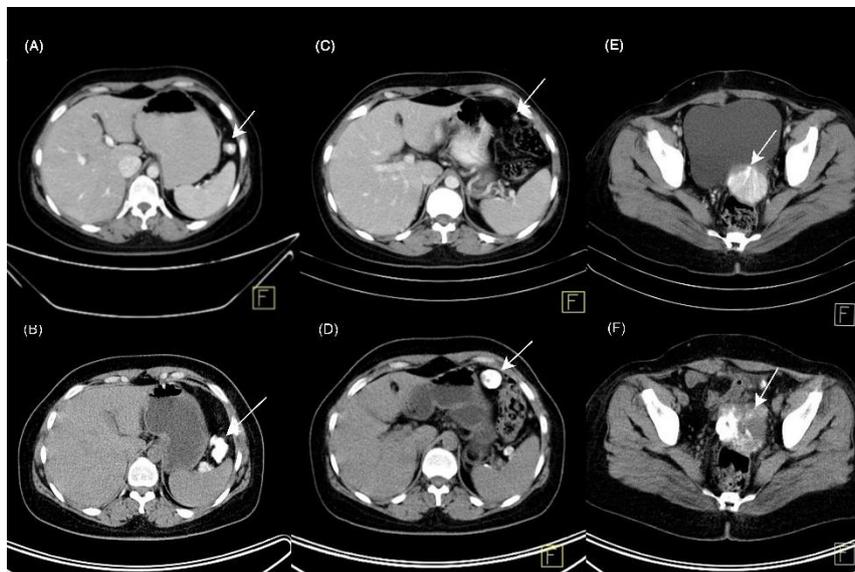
Comparison of CT images dated September 2018 (A, C, E) with the scan performed on September 2019 (B, D, F). Axial CT images reveal significant increase in size and heterogeneity of the tumoral deposits
